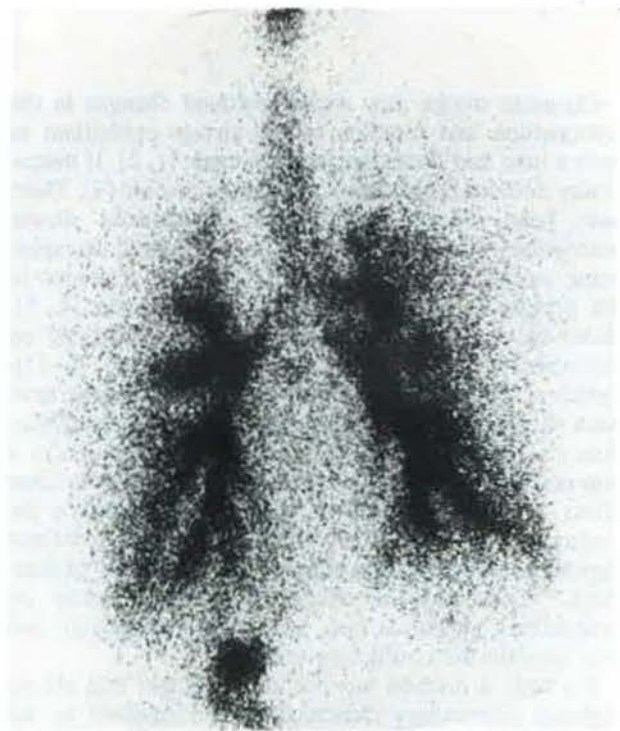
An example of a bronchoscintigram. The large airways from the trachea to the segmental bronchi are visualized.
